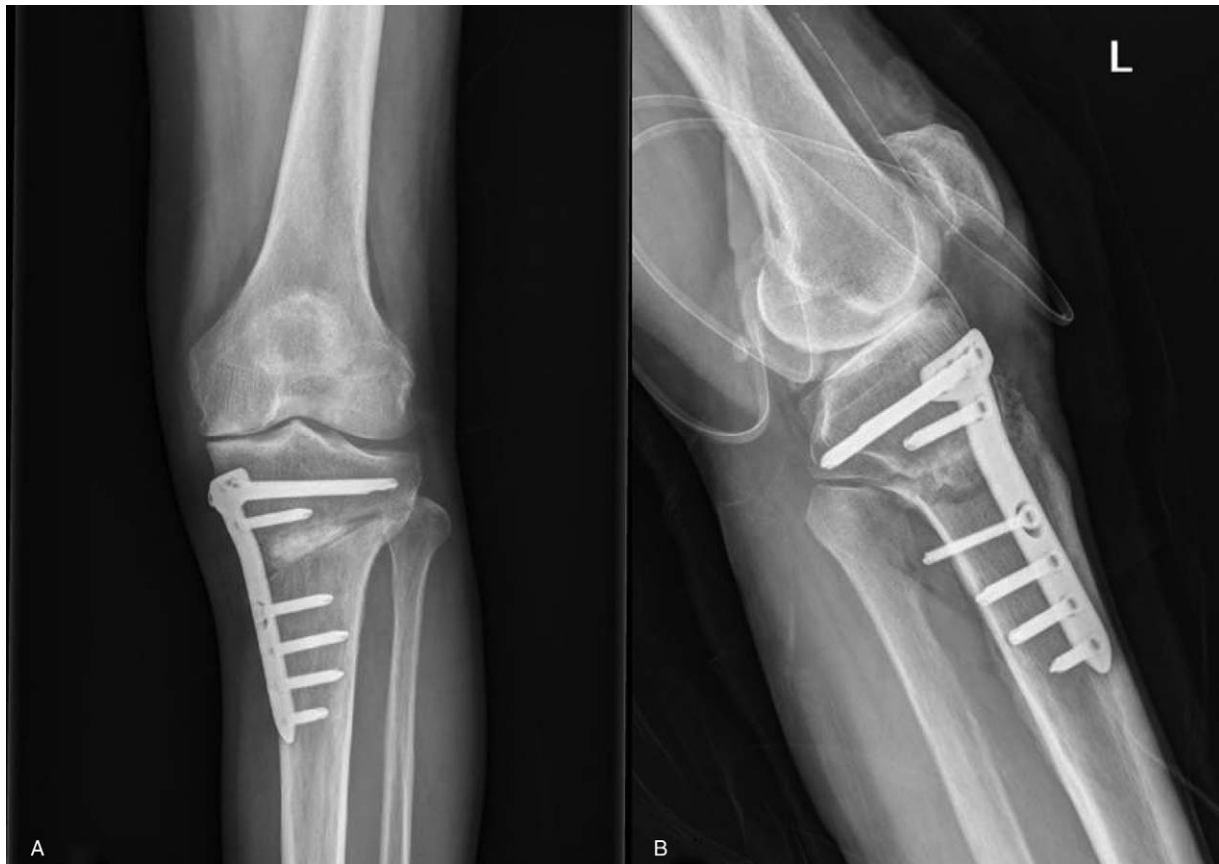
(A) The opening wedge high tibial osteotomy was performed using a locked plate. (B) On lateral projection conventional radiograph, the first distal screw was protruded towards the posterolateral aspect of proximal tibia.
